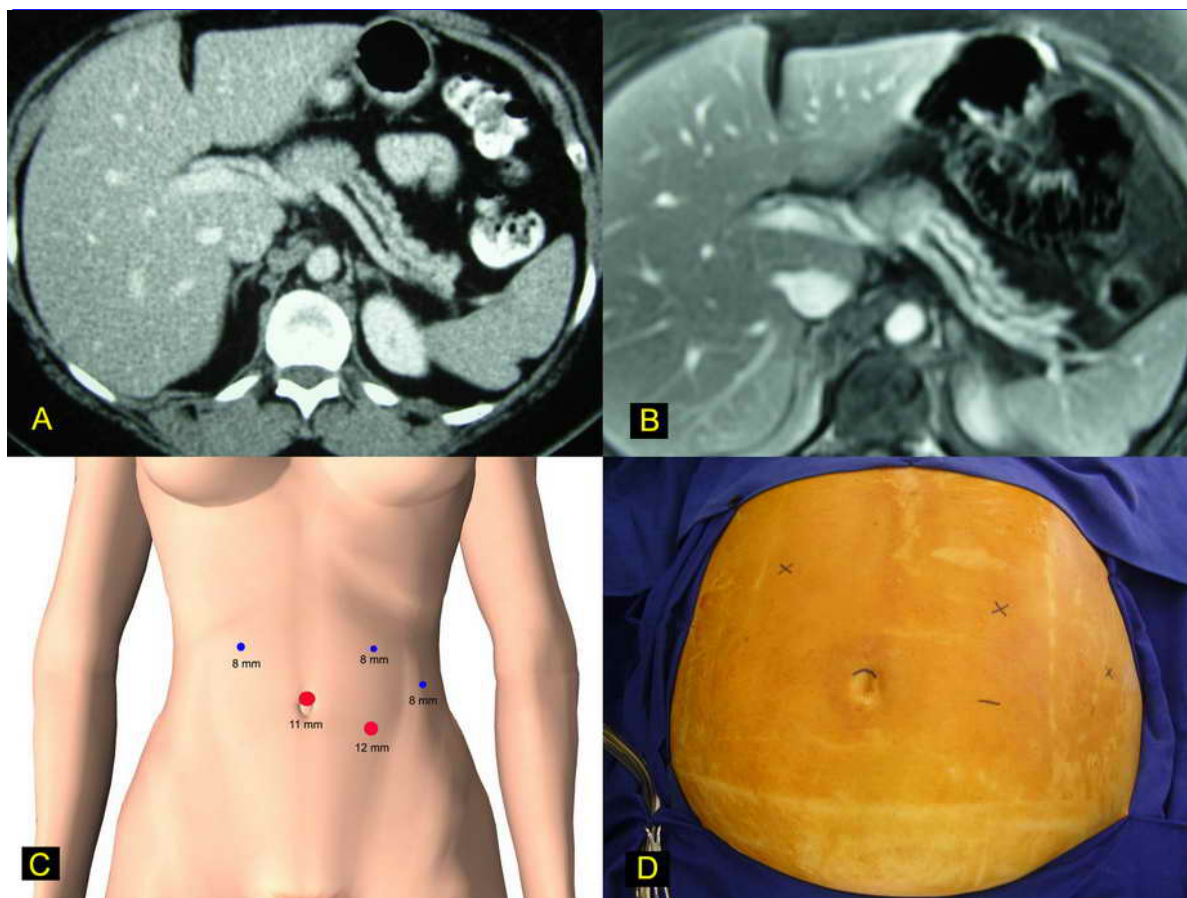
Robotic pancreatic resection. (A) Preoperative computed tomography scan shows an atrophic distal pancreas with dilatation of the main pancreatic duct. (B) Preoperative magnetic resonance imaging suggests an intraductal neoplasm in the neck of the pancreas with atrophy of the body and tail of the pancreas. (C) Five trocars were used: three 8-mm trocars, one 11-mm trocar, and one 12-mm trocar. (D) The patient was placed in a right semilateral decubitus position.
